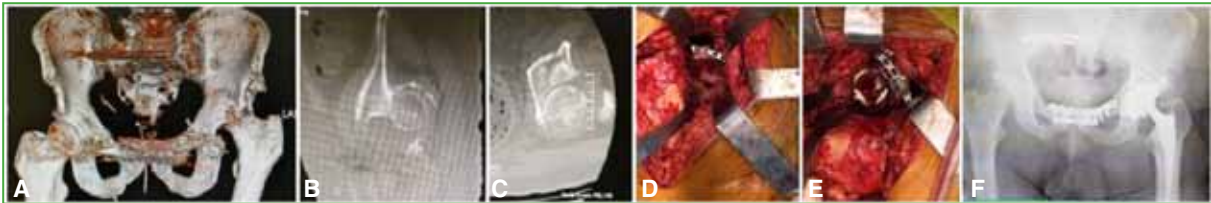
54-year-old man with a chronic fracture-dislocation of more than 12 months' duration, due to cardiovascular contraindications and a history of pelvis osteosynthesis with a dislocated left hip. A. 3D tomography of the pelvis. B and C. Computed tomography scans, selected slices, showing chronic left hip dislocation. D. Femoral head autograft plus osteosynthesis with a 3.5 mm plate. E. Dual-mobility cementless acetabular component implant with ischial, ilial, and pubic anchors. F. Postoperative anteroposterior pelvis radiograph of hybrid total hip arthroplasty, showing excellent clinical and radiographic evolution.
